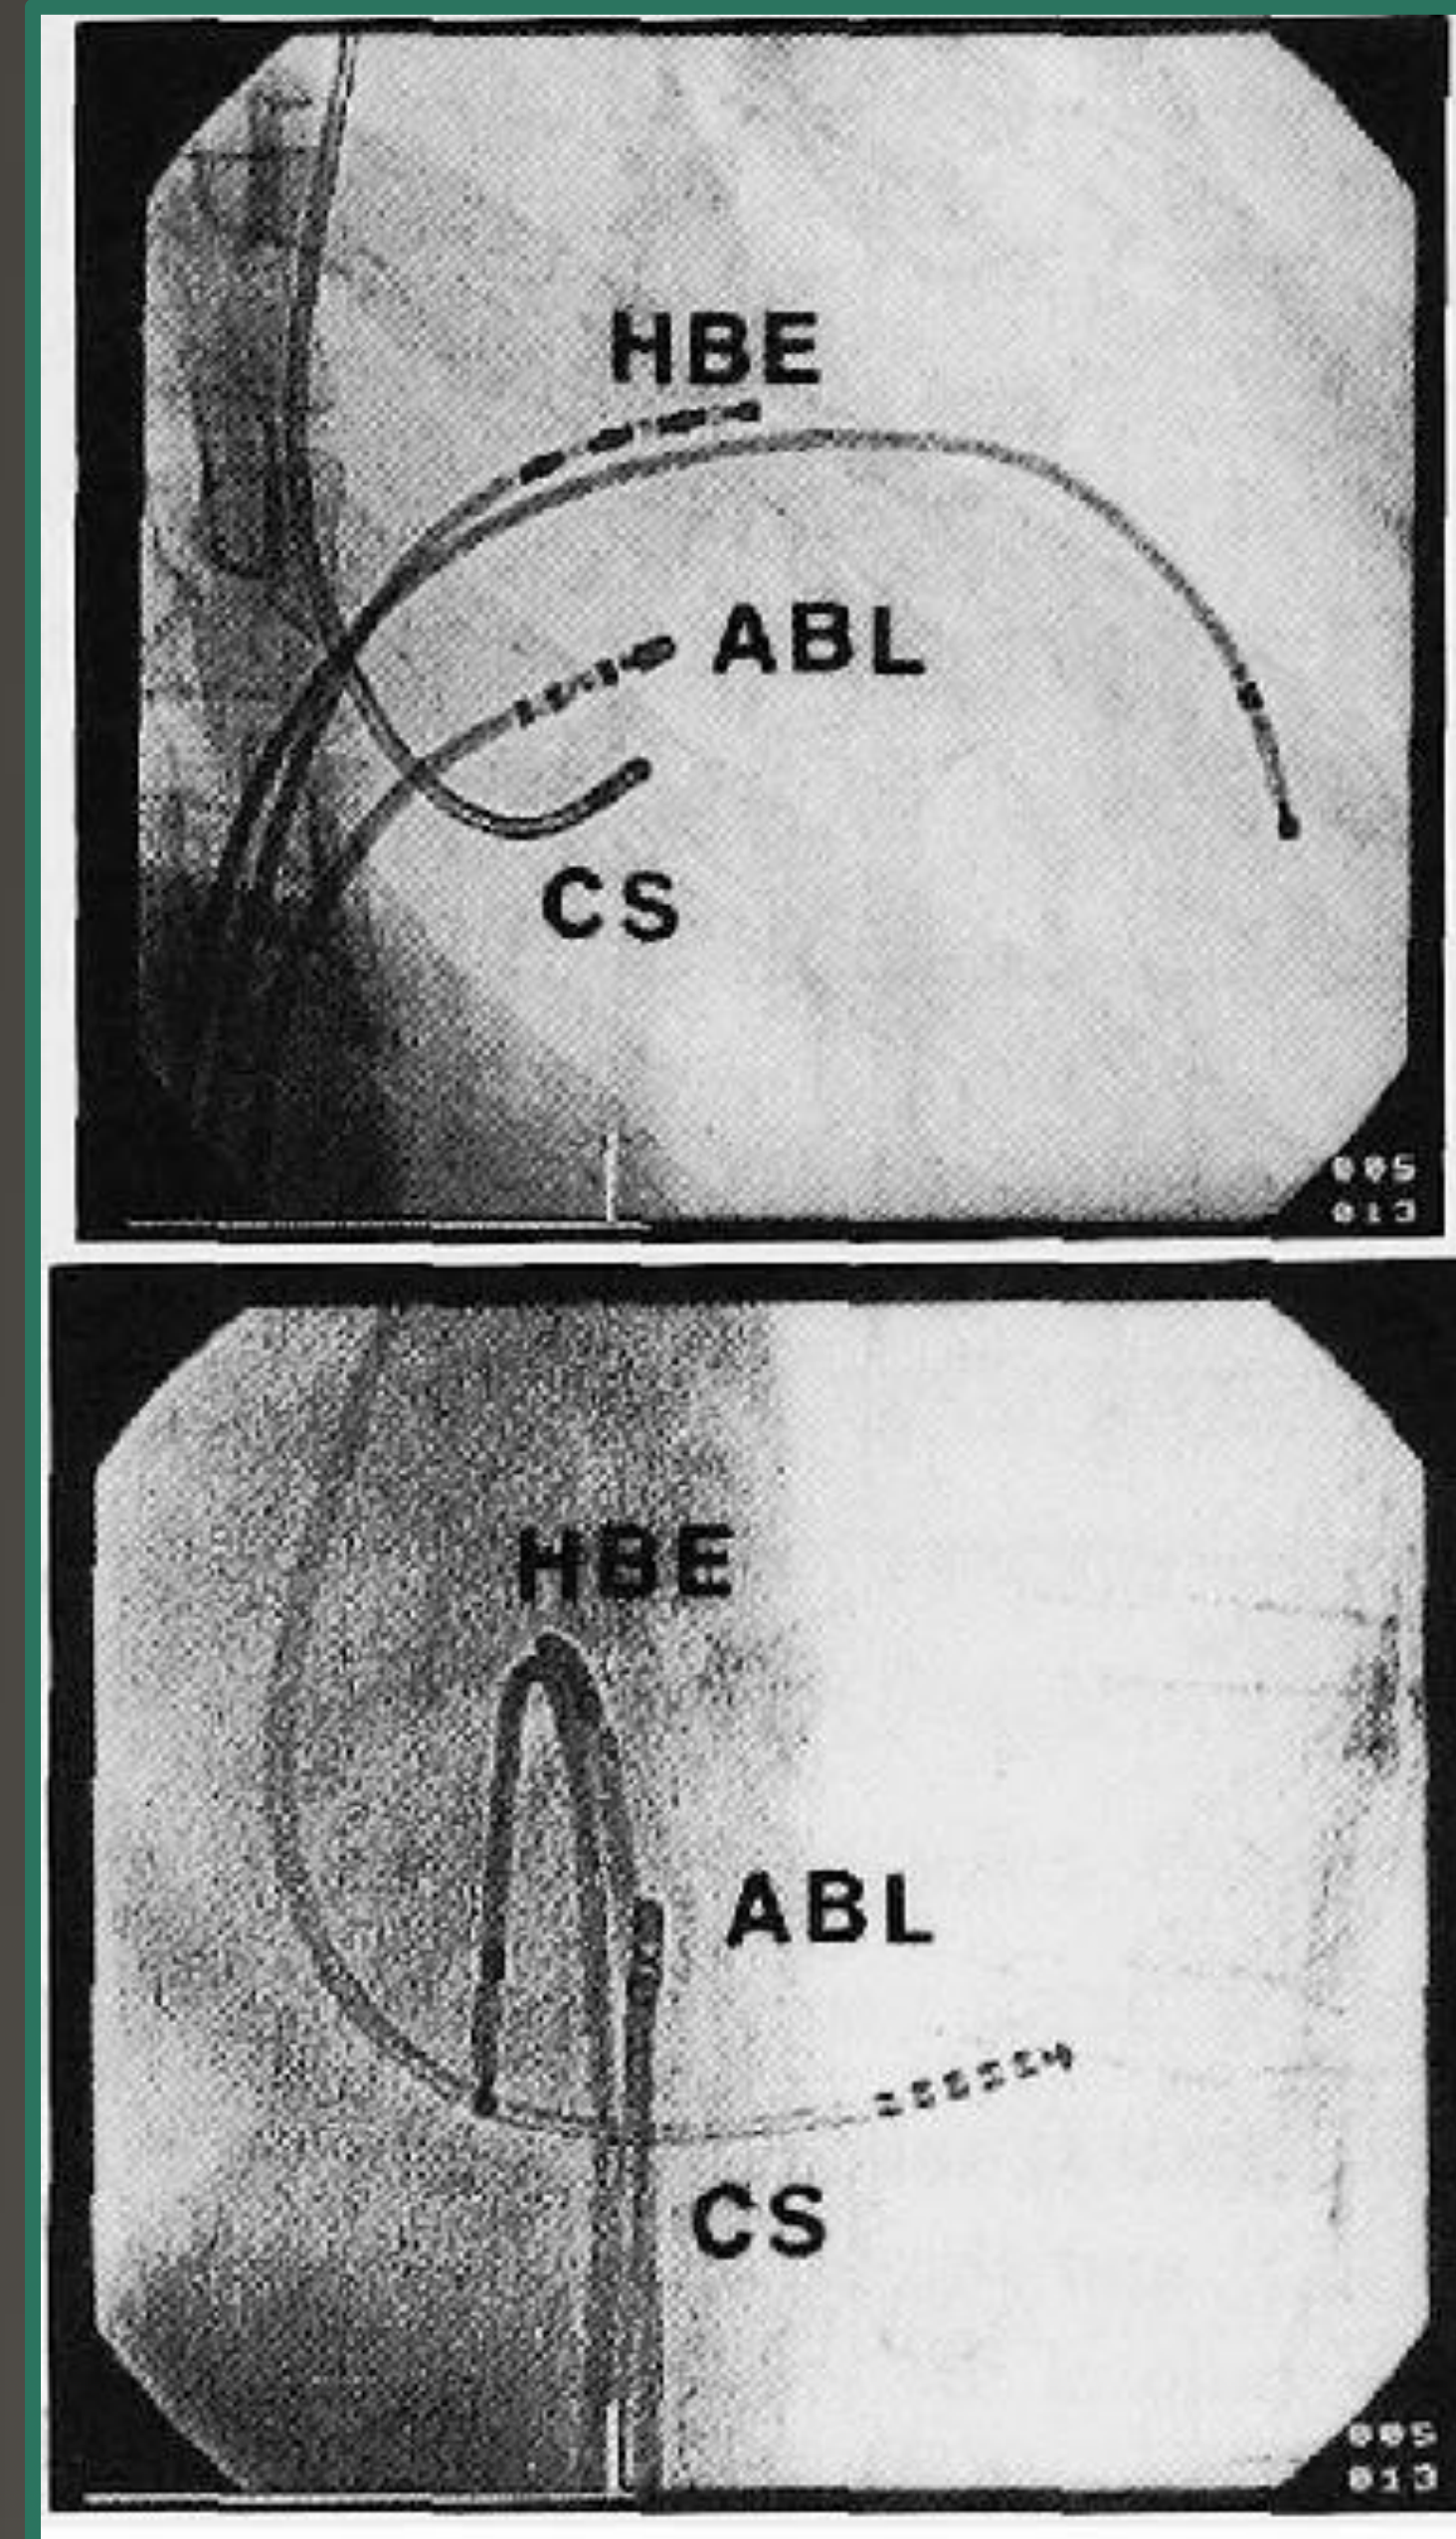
Above is a radiographic image taken during an ablation procedure. The most advantageous spot for ablation is marked ABL, and an ablation catheter is found in that spot.³
